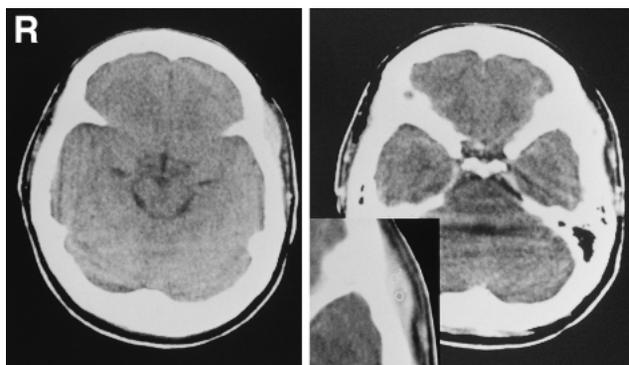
Computed tomography scans showing a high density mass in the left temporal subcutaneous tissue (left) with marginal enhancement (right).
